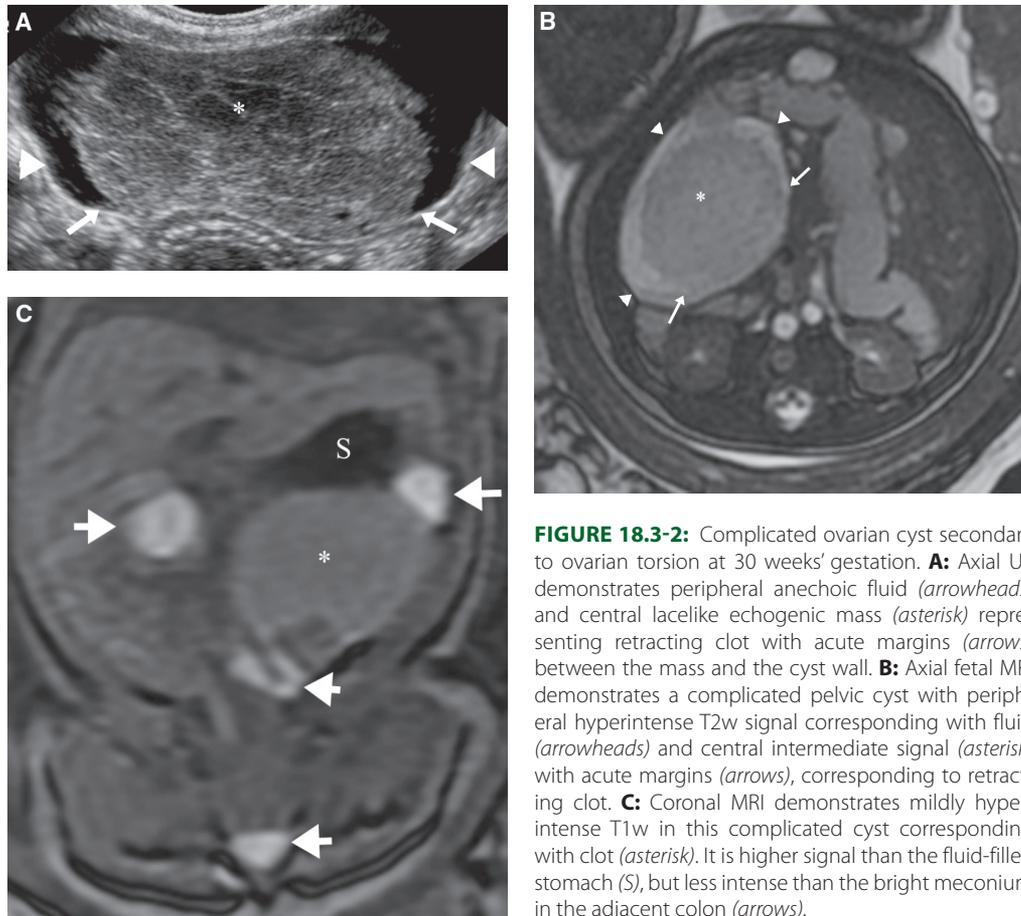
Complicated ovarian cyst secondary to ovarian torsion at 30 weeks' gestation. A: Axial US demonstrates peripheral anechoic fluid (*arrowheads*) and central lacelike echogenic mass (*asterisk*) representing retracting clot with acute margins (*arrows*) between the mass and the cyst wall. B: Axial fetal MRI demonstrates a complicated pelvic cyst with peripheral hyperintense T2w signal corresponding with fluid (*arrowheads*) and central intermediate signal (*asterisk*) with acute margins (*arrows*), corresponding to retracting clot. C: Coronal MRI demonstrates mildly hyperintense T1w in this complicated cyst corresponding with clot (*asterisk*). It is higher signal than the fluid-filled stomach (S), but less intense than the bright meconium in the adjacent colon (*arrows*).
